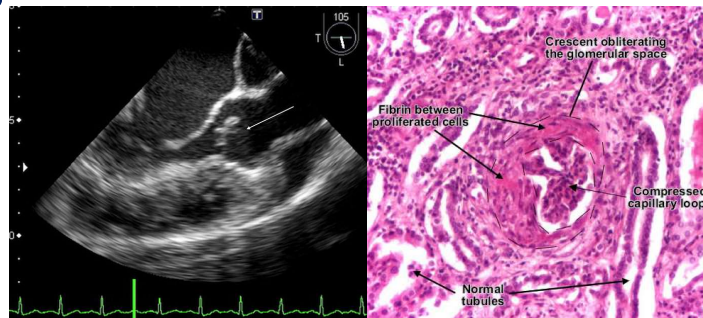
(left) Mobile Vegetations on Aortic valve as seen on Transesophageal echocardiogram.
